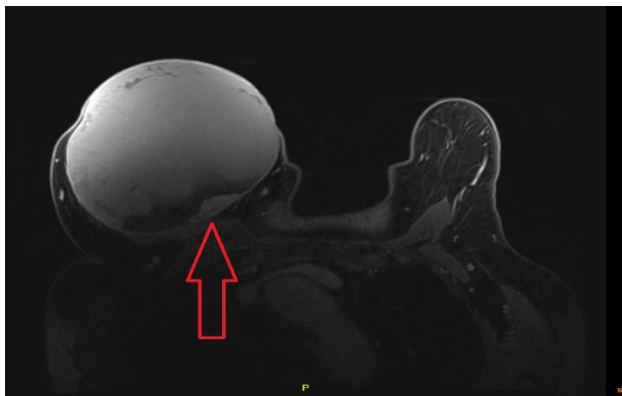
MRI of right breast, showing enhancing nodule in posteromedial wall of cystic cavity (red arrow).
